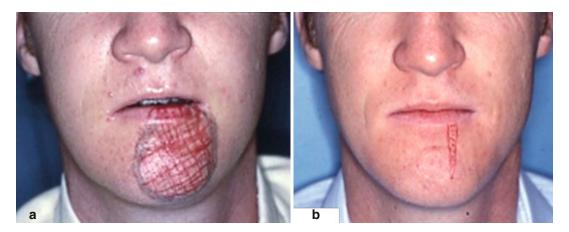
A 33-year-old male who sustained a left mental nerve severance during a genioplasty. The nerve injury was not repaired at the time of surgery. (a) Area of total sensory loss outlined on left lower lip and chin 6 weeks following original surgery. (b) Subsequently, the left mental nerve was repaired with a neurorrhaphy. Six months following nerve repair, only a small area of altered sensation remains. Within the outlined area, the patient responded normally to painful stimuli and to light touch at a threshold greater than the normal right side. Two-point discrimination threshold in the left lower lip was 10 mm, compared to 5 mm on the normal right side panoramic imaging, computed tomography, or magnetic resonance imaging may be included in the radiographic evaluation. Basic imaging studies are often helpful in the assessment of the patient with a trigeminal nerve injury, and once an abnormality is seen on a plain film, additional images (e.g., cone-beam computed tomography (CBCT)) may be indicated. Examples of information obtained from imaging studies that can be helpful in the assessment of nerve-injured patients are shown in Fig. 10.19. These significant findings may include retained roots, retention of foreign bodies (e.g., broken instruments), mandible fracture, fixation plates and screws, and iatrogenic injuries from rotary instruments which may be in proximity to the IAN or LN. For further discussion of imaging, the reader is referred to Chap. 11.
